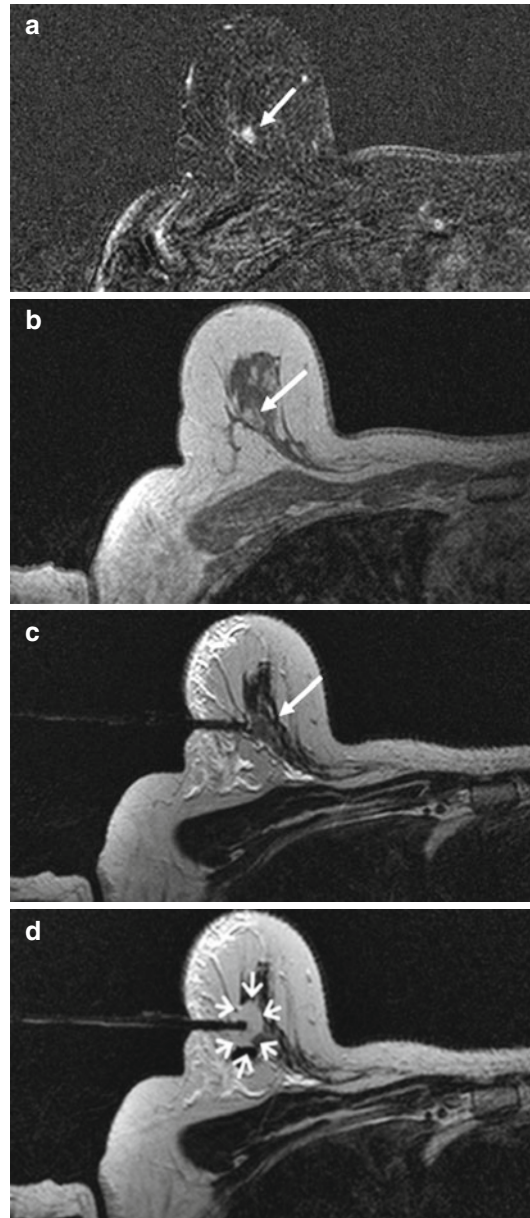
41-year-old patient with a history of a lobular carcinoma in situ of the left breast. Breast MR imaging showed a 6-mm mass-like lesion in the upper outer quadrant of the right breast (*white arrow*). Mammography and a second-look ultrasound did not reveal a correlate for the MR imaging finding. Vacuum biopsy with a 9-G system (ATEC, Suros) revealed an invasive ductal cancer, pT1b, pN0, G3. 5a-b: dynamic breast MR imaging of the right breast, axial orientation, T1-weighted 2D gradient echo TR/TE/FA 290/4.6/90°; (a) subtracted image, (b) first post-contrast image; (c): T2-weighted image (TR 3000/TE120) before vacuum biopsy, after placing an obturator, (d): T2-weighted image after vacuum biopsy and flushing the biopsy cavity with saline. The biopsy cavity can accurately be delineated on the T2-weighted TSE image (*white arrows*)
